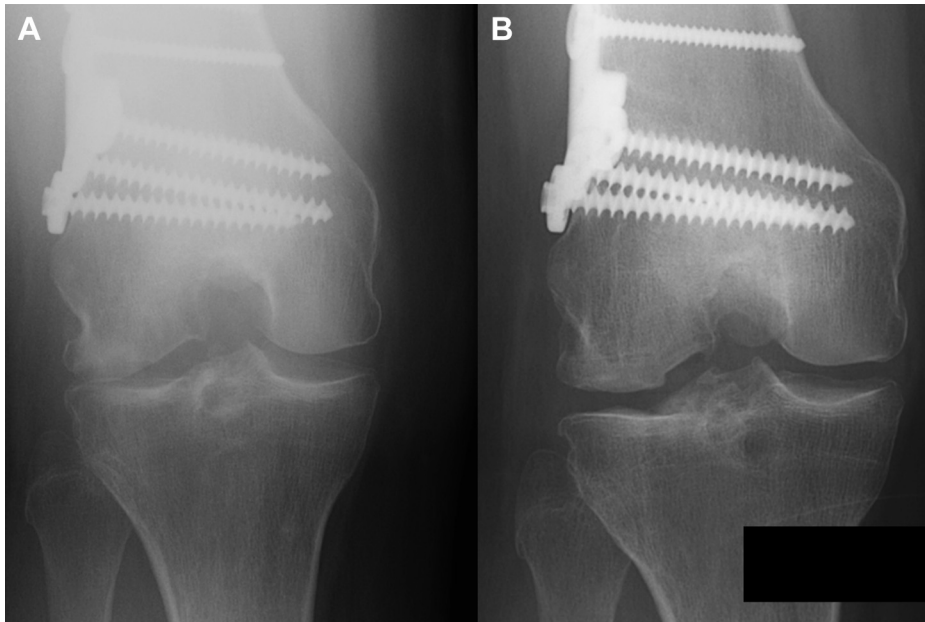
(A) Preoperative and (B) postoperative radiographs of the right knee of patient 6 showing radiographic improvement after revision meniscus transplantation, although this patient would not choose to undergo surgery again.
